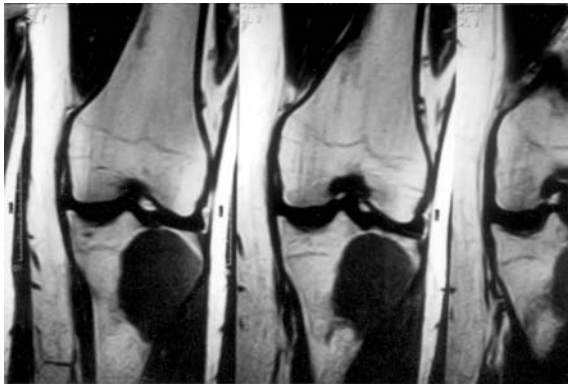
Pre-operative MRI for a patient with GCT upper tibia.
